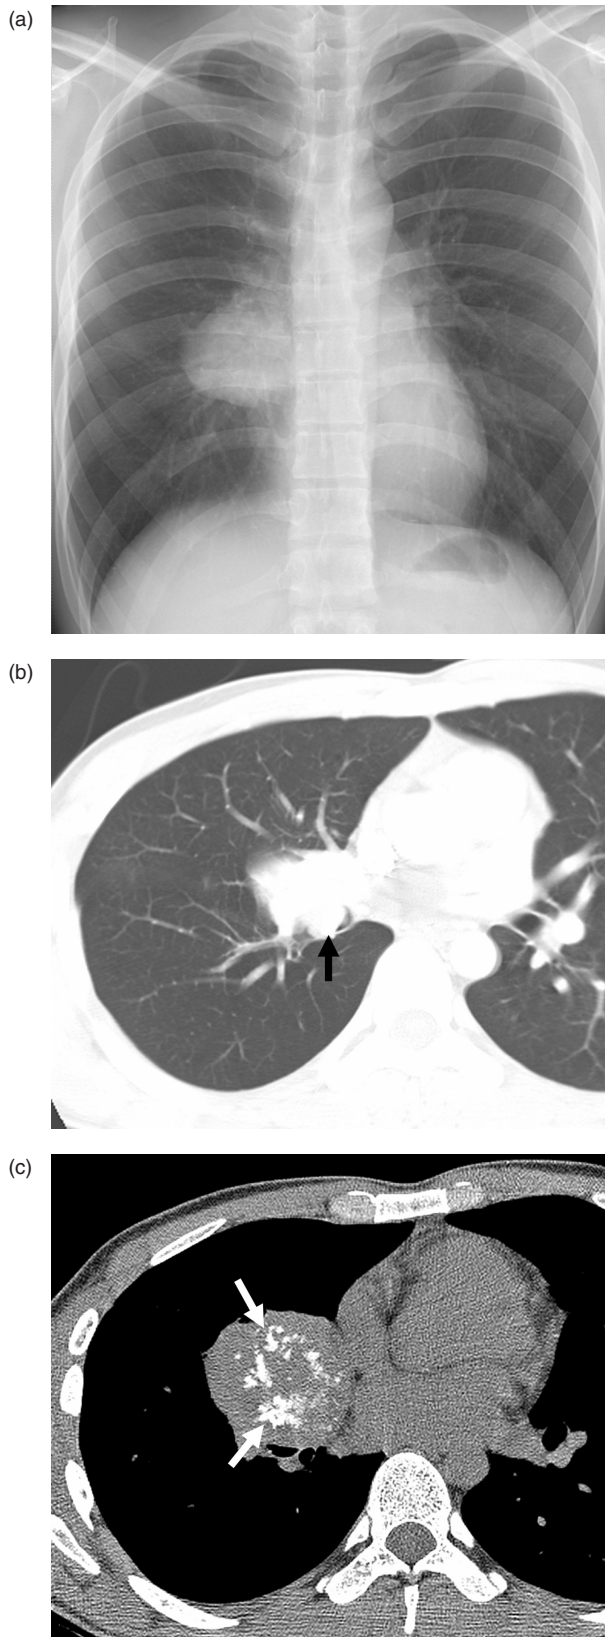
A 24-year-old man with typical carcinoid. (a) Chest radiograph shows a large mass in the right infrahilar area. (b) Transverse unenhanced CT scan (5-mm section thickness, 130 mAs) obtained at the level of the left lower lobar bronchus demonstrates the upper
